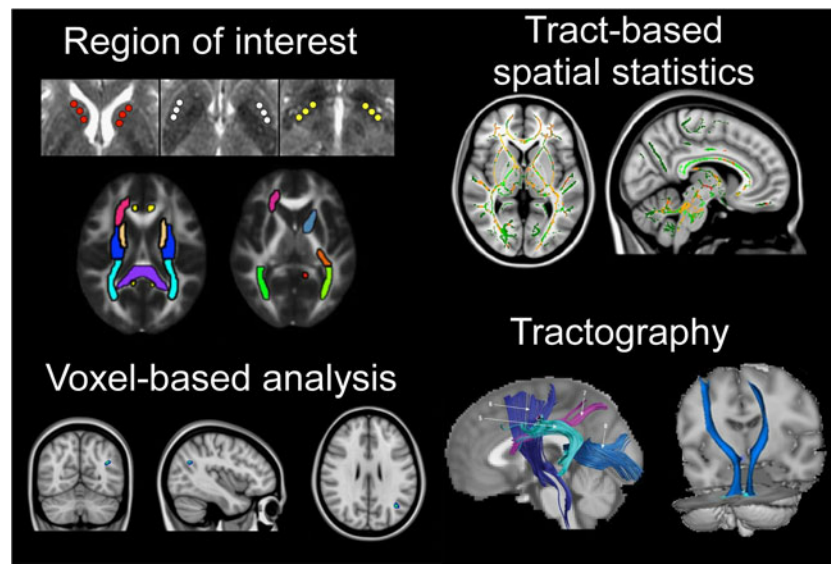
Visual representations of the major diffusion magnetic resonance imaging analysis methods that are currently in use. *Clockwise from top left*: manual selection of regions of interest; automated tract-based spatial statistics aligns a combined fractional anisotropy map on a fractional anisotropy skeleton; tractography involves tract reconstruction based on
